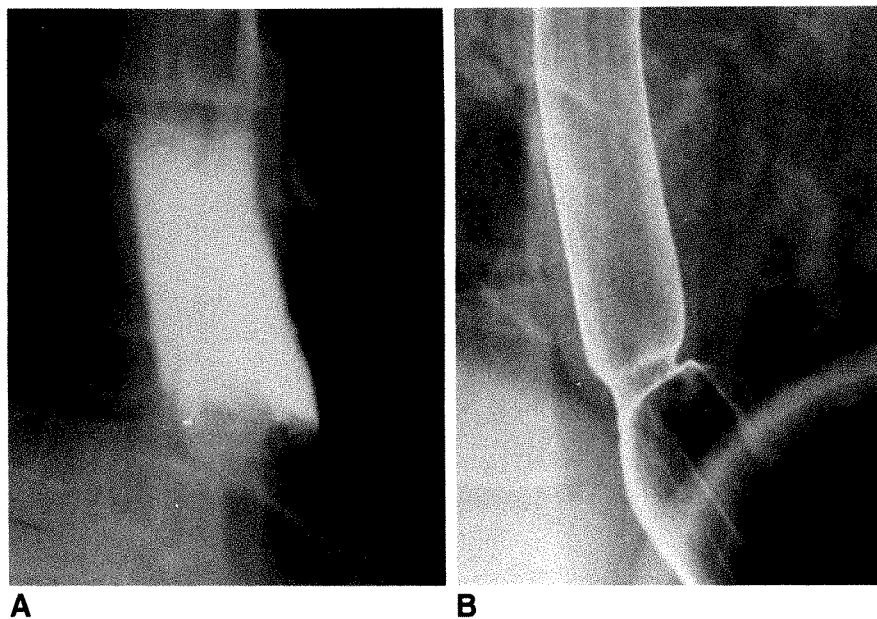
A, Pretreatment radiograph shows distal esophageal food impaction causing obstruction in a 46-year-old man who had been eating chicken.
